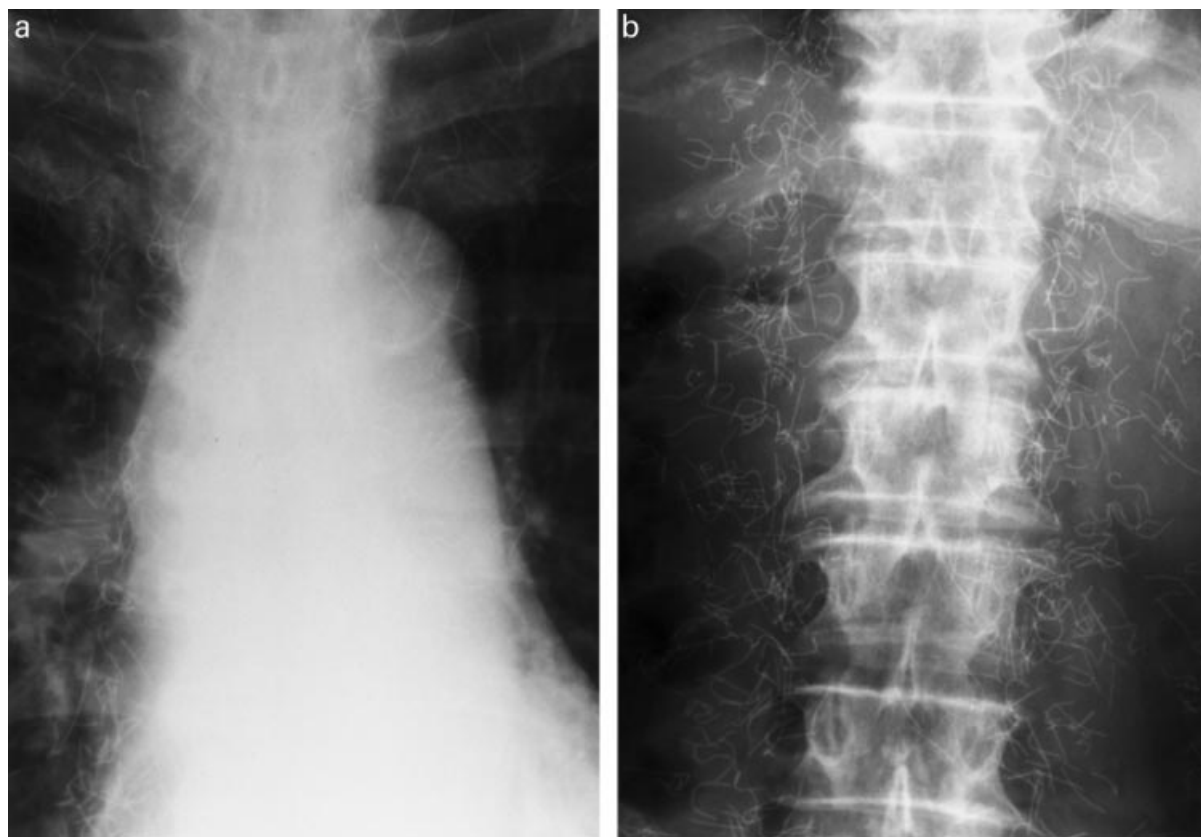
Chest (a) and abdominal (b) X-rays show hundreds of needles left around the vertebrae.
